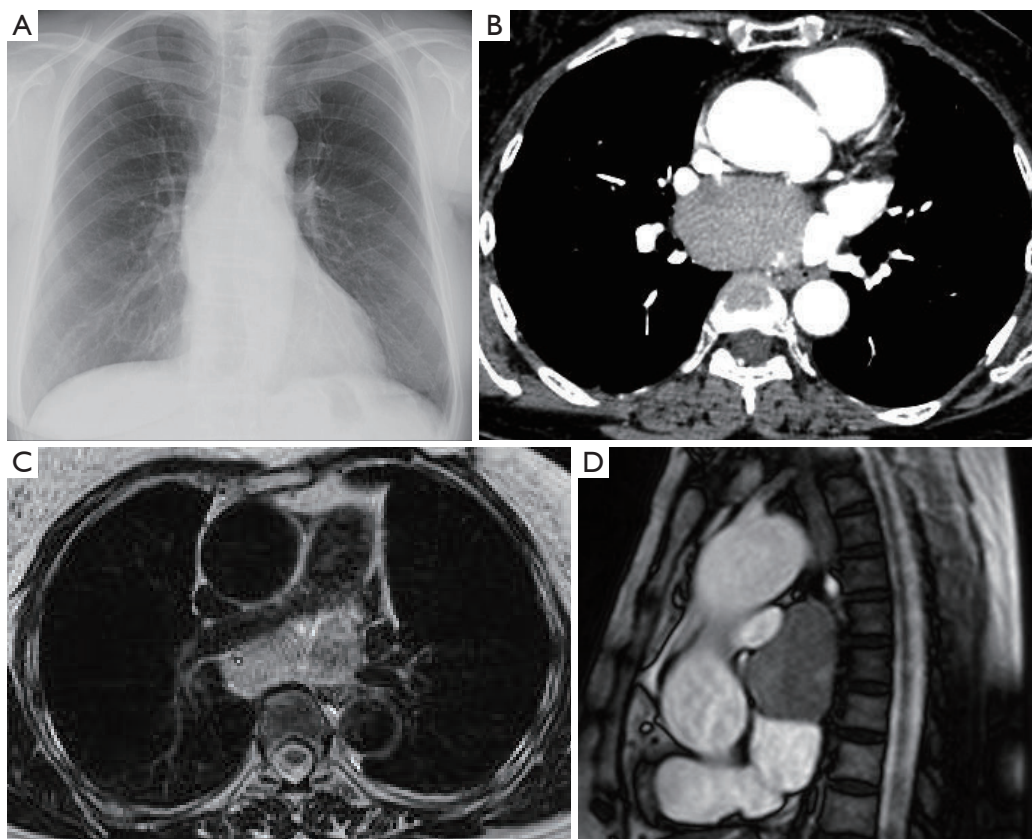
Findings on chest X-ray, computed tomography (CT) and MRI. (A) A mass overlapping the cardiac silhouette was detected on chest X-ray; (B) a large cystic mass measuring 60 mm was detected on MDCT, the mass compressed the left atrium and the right superior pulmonary vein, it also lay adjacent to the right pulmonary artery and the left superior pulmonary vein; (C) a high intensity in T2-weighted image; (D) the mass had an intermediate intensity on cine MRI. MDCT, multiple detector computed tomography; MRI, magnetic resonance imaging.
